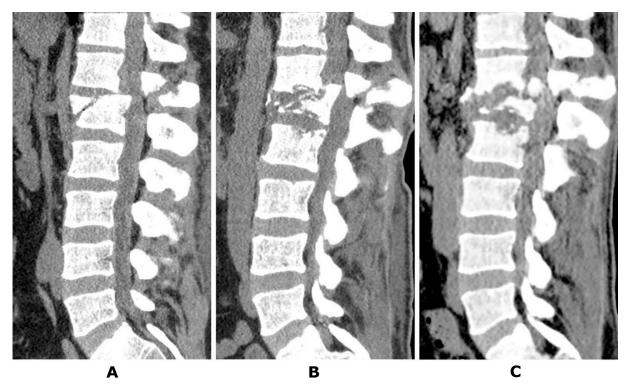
Patient T., 41 years old. CT scans of the lumbar spine: A – the day after the injury; B – after 1.5 months; C – after 2 months post-injury (details in the text)
